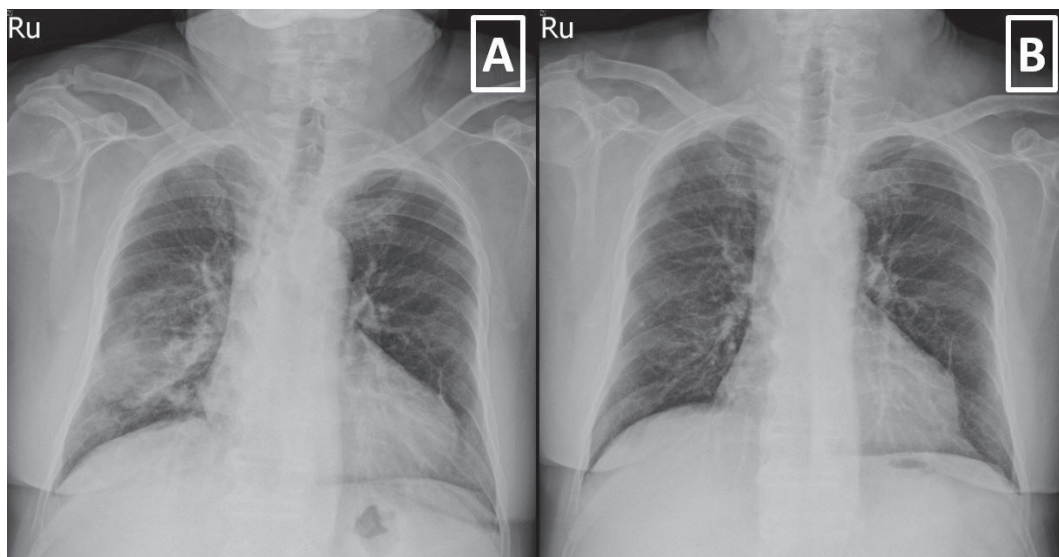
Chest Radiographs. Panel A: Chest radiograph demonstrating a consolidative opacity of the right lower lung. Panel B: Resolution of the opacity after 4 weeks.
